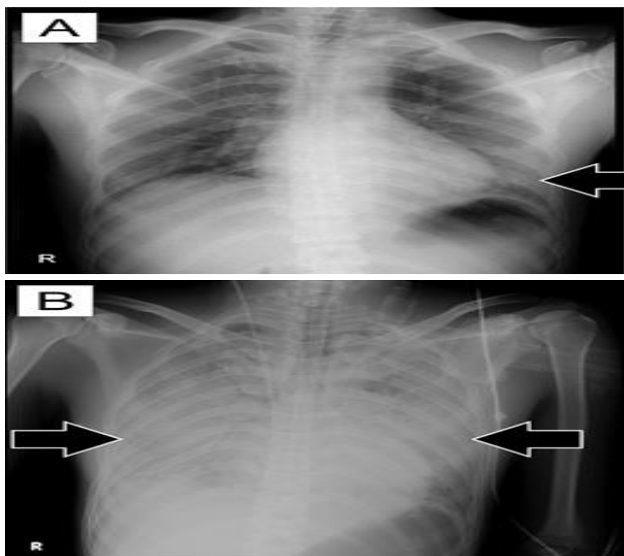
(A and B): Chest x-ray of initial admission and day two of treatment.
